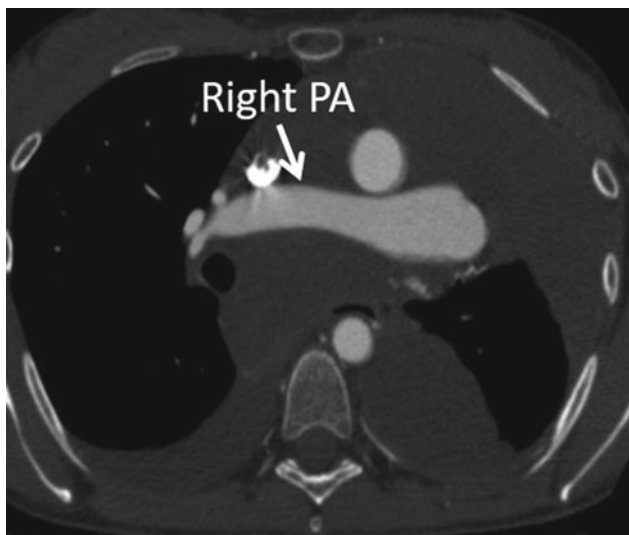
CT pulmonary angiogram after 8 months of pazopanib treatment shows alleviation of the right pulmonary artery obstruction
